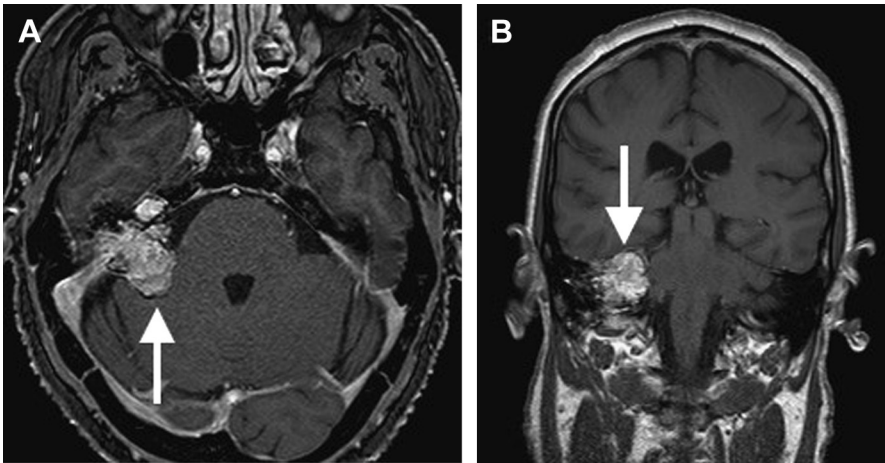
(A) Axial cut T1 MRI with contrast showing a left endolymphatic sac tumor. The tumor is designated by the white arrow. (B) Coronal cut T1 MRI with contrast showing a left endolymphatic sac tumor. The tumor is designated by the white arrow.
